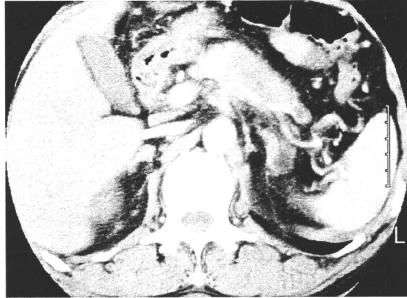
On abdominal CT, a low-density area was seen running from the pancreatic body, involving the celiac and splenic arteries.
